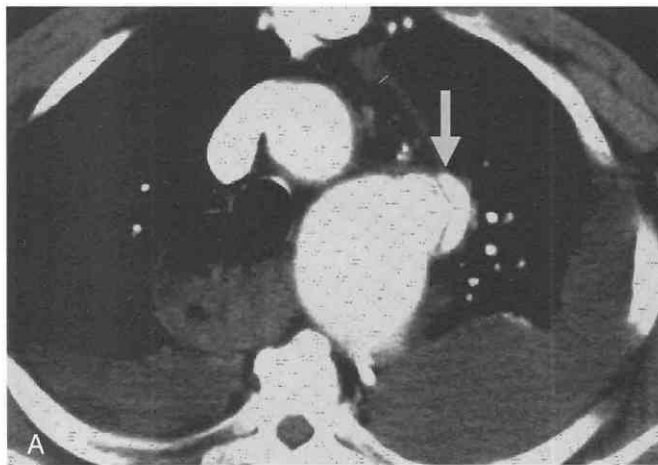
A, Axial CT scan in a patient with known aortic aneurysm and findings suspicious for possible dissection flap involving the descending aorta (*arrow*). B, Axial CT scan superior to A shows the full course of the superior intercostal vein (*white arrow*). Note the separate medial dissection flap (*black arrow*).
